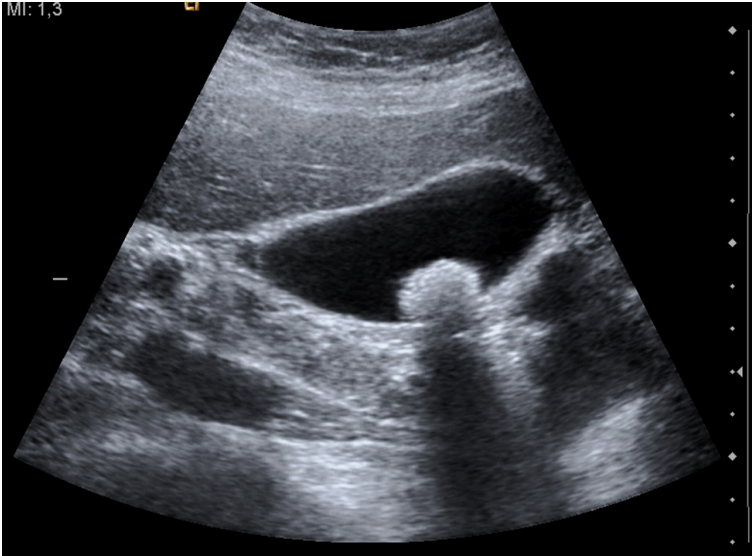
Ultrasound image of gallbladder stone. [Ultrasound image of gallbladder stone Gallstone 091937515](#) by Nevit Dilmen licensed under [CC BY-SA 3.0](#)
